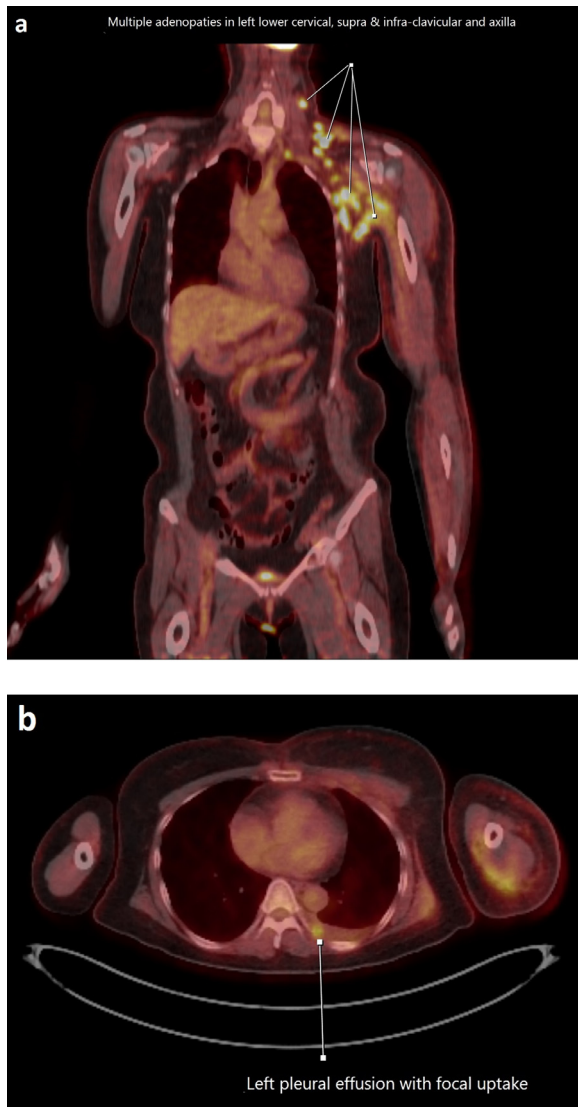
NM Whole body PET-FDG. Injected activity 177 MBq. No convincing breast primary. Extensive left axillary adenopathy extending to the lower cervical, subpectoral and the left internal mammary chain (A). New effusion with focal uptake (SUV 10.8) representing possible pleural disease (B).
